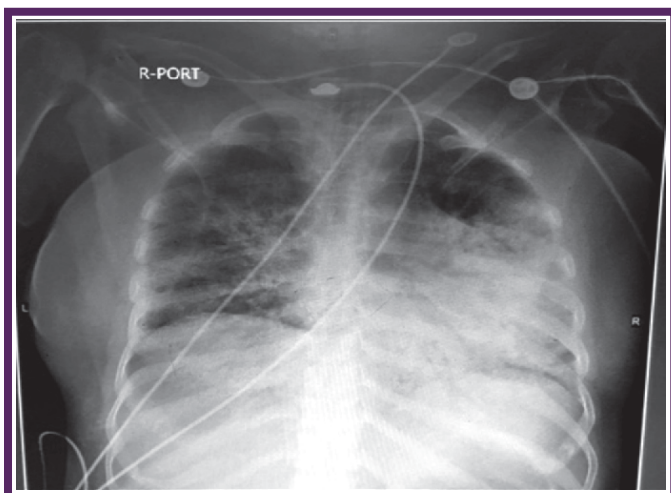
Chest radiograph post intubation, showing ETT in-situ and bilateral infiltrates in both lung fields, predominant in left middle zone
